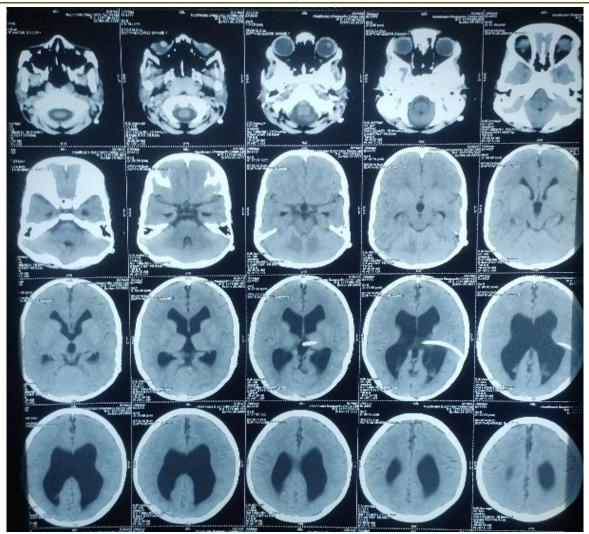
Postoperative CT scan of the brain showing the inaccurate location of the ventricular catheter tip
